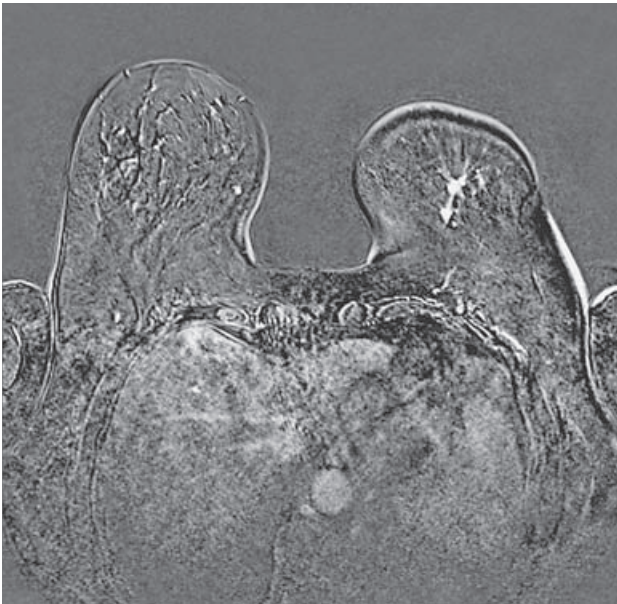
The dynamic contrast-enhanced MRI of the breast.
